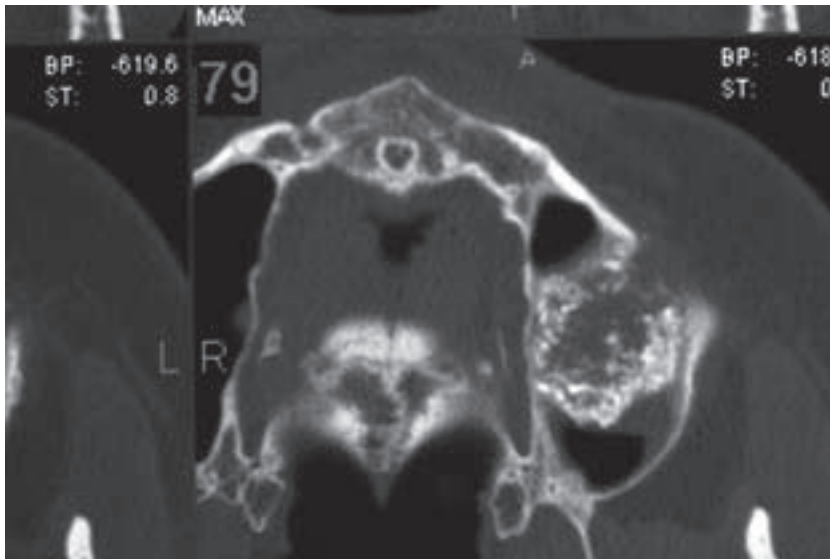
Axial CT view showing an infected core with surrounding graft.
